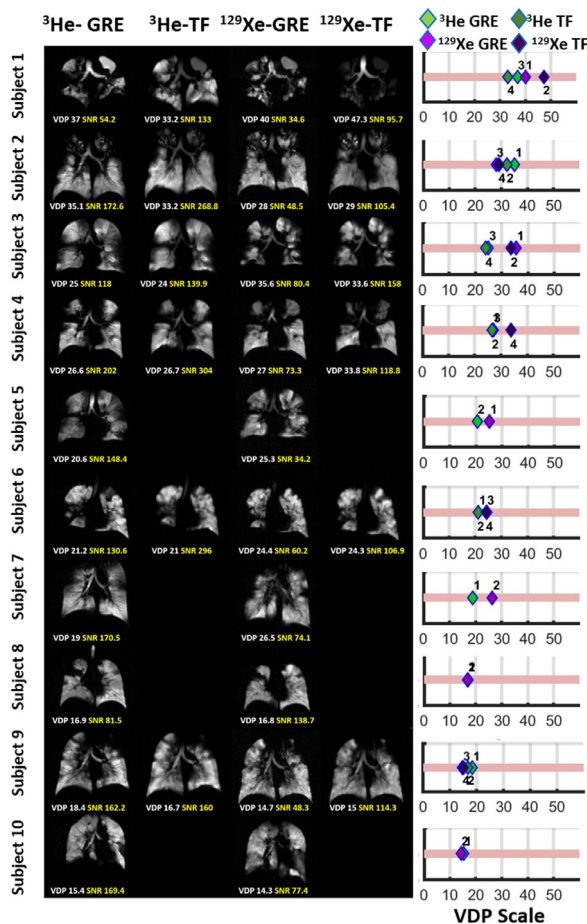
Representative slices of ^3He and ^{129}Xe MR images for all subjects alongside whole-lung VDP measures for each scan. The numbers in the VDP scale represents the scan order.
